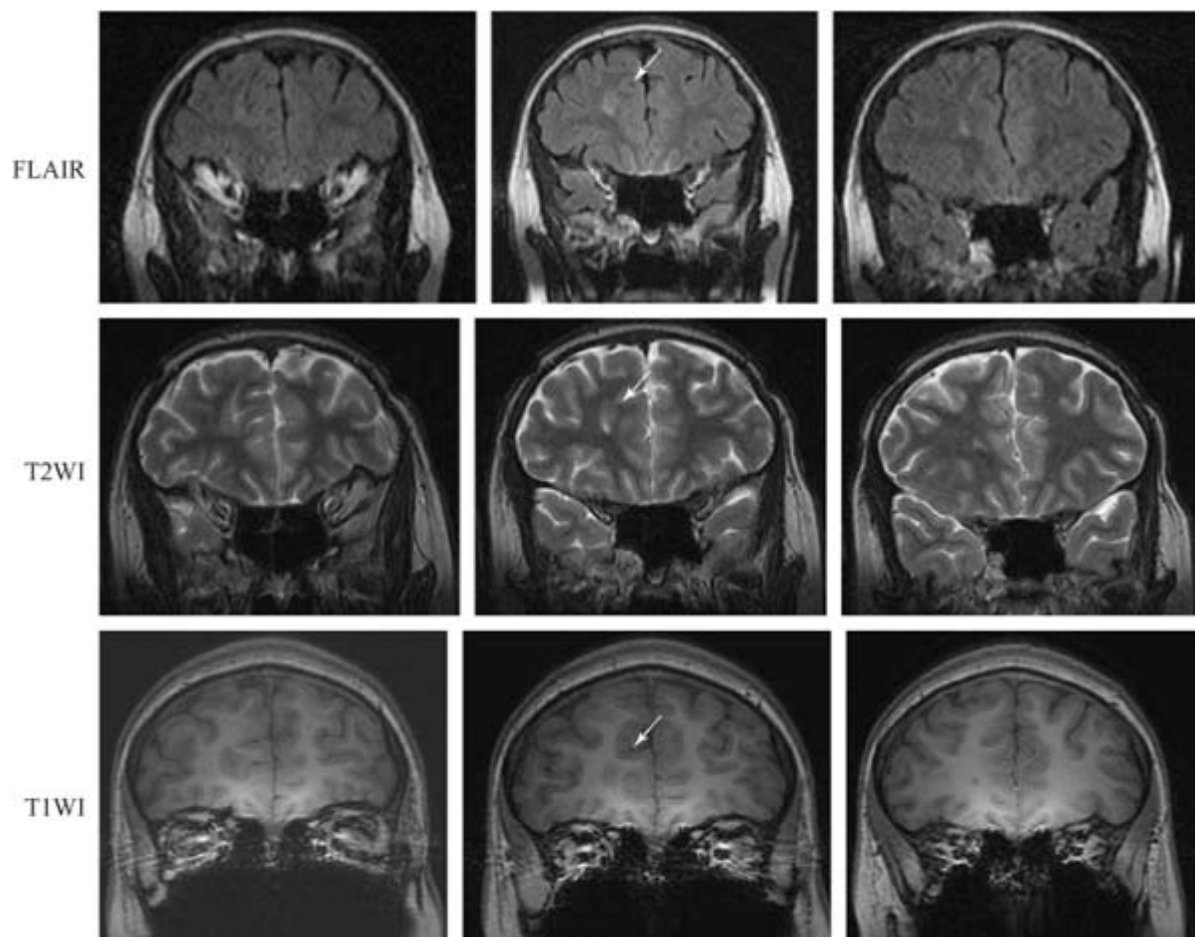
A typical imaging sequence (*arrow*). Note that the focal cortical dysplasia is visible in all sequences but is much easier to identify in the fluid-attenuated inversion recovery (FLAIR) sequence because of the easily seen abnormal and focal signal. T1WI, T1-weighted image; T2WI, T2-weighted image.
